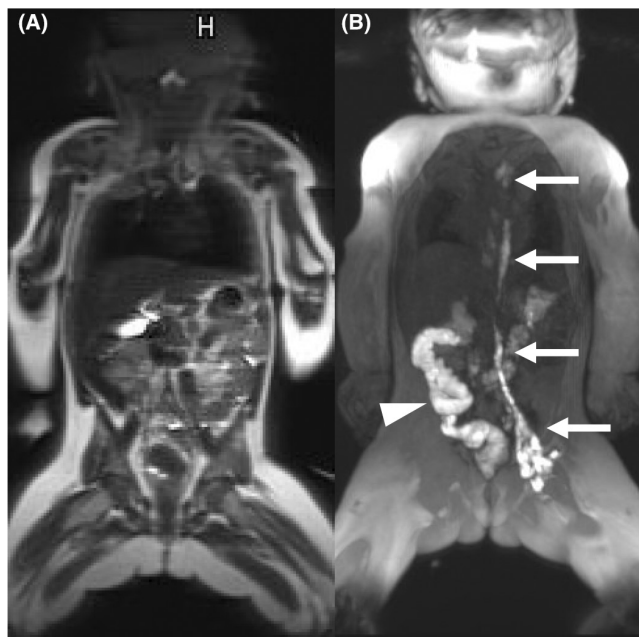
Dynamic Contrast-enhanced MR Lymphangiography after treatment with trametinib. (A) Coronal T2 weighted image, now without subcutaneous edema or pleural fluid. (B) Coronal T1 weighted MR image after intranodal contrast injection. The arrows indicate the contrast in the iliac lymphatic vessels and the thoracic duct. The arrow head indicates a normal bowel. There is no dermal backflow.
